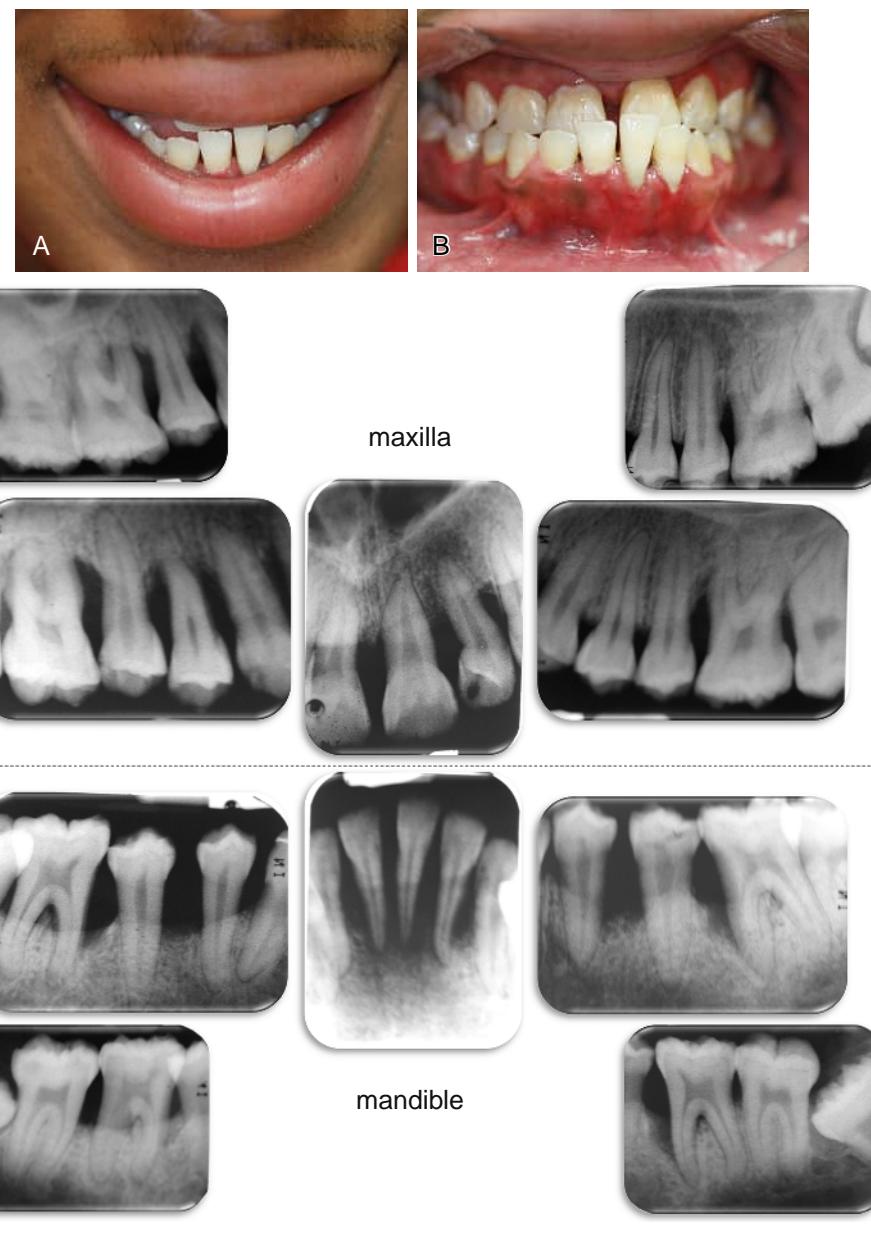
Images of a 19-year-old African American male diagnosed with stage IV grade C generalized periodontitis (previously termed generalized aggressive periodontitis or early-onset periodontitis) within the permanent dentition. (A) Patient's smile. (B) Patient in occlusion, anterior view. (C) Intraoperative periapical series of all teeth showing generalized severe bone loss of most teeth. (Courtesy of Dr. Luciana Shaddox)
